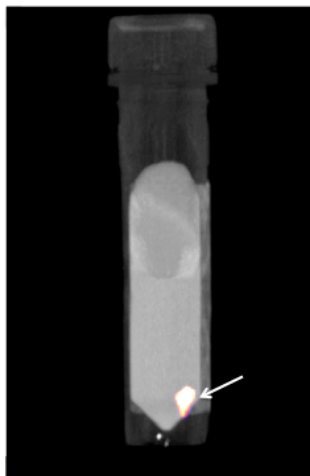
SPECT/CT image of 1 x 10⁶ Jurkat cells (arrowed) in an eppendorf, labeled with 0.6 MBq ¹²⁵I-DM.
